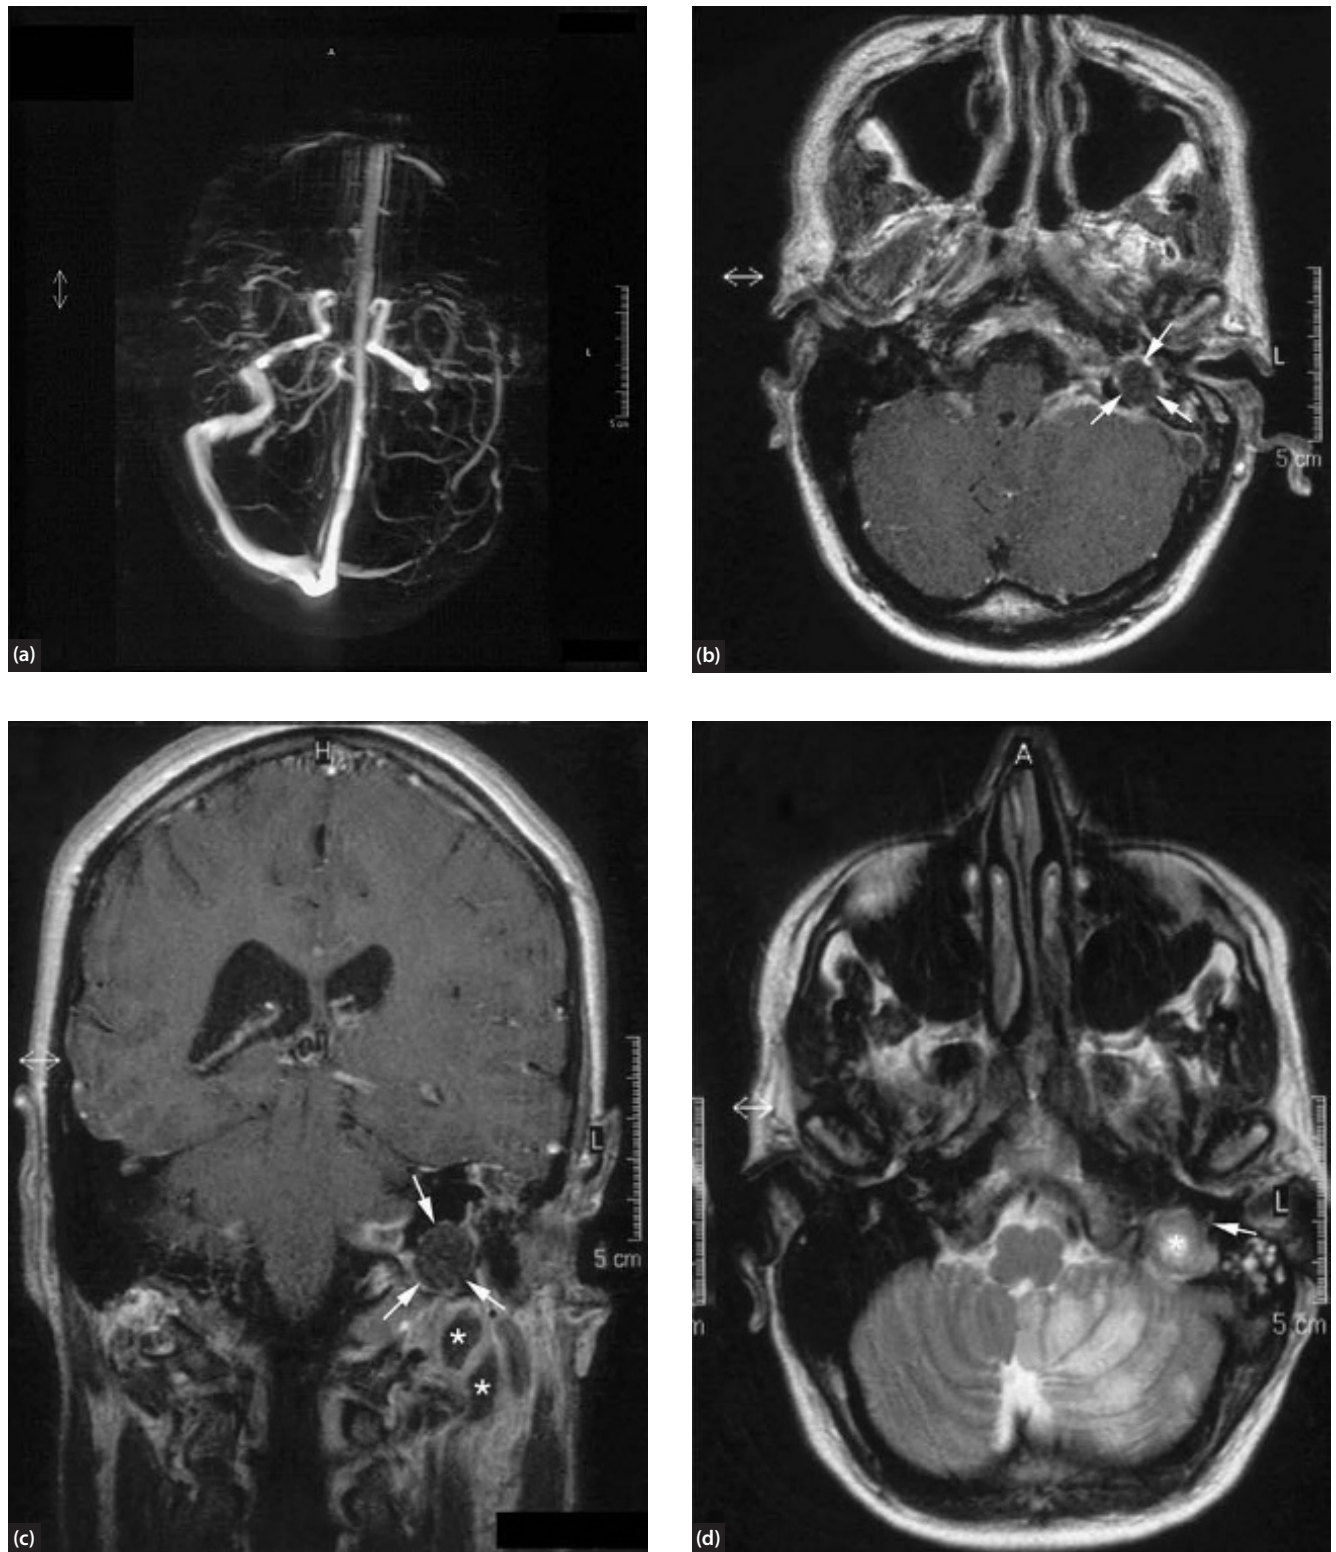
A 42-year-old man presented with fever, headache and 40 dB conductive hearing loss on the left side. Moreover, there were clinical signs of involvement of the cranial nerves VII (House-Brackmann II), IX, X, XI and XII. (a) MRA showing absence of flow in the left transverse sinus and sigmoid–jugular complex. (b) T1-weighted coronal MRI after administration of gadolinium. Mass lesion in the left jugular foramen (arrows). Multiple cystic lesions in the upper neck (asterisks). (c) T1-weighted axial MRI after administration of gadolinium. Note mass lesion in the jugular foramen (arrows). (d) T2-weighted axial MRI. The lesion in the left jugular foramen is depicted as a hyperintense area (asterisk); a small band suggests the presence of a connection with the middle ear (arrow); this was confirmed during surgery. Diagnosis (made intra-operatively): cholesteatoma in the left jugular foramen with thrombosis of the sigmoid–jugular complex and multilocular abscesses in the upper neck.
